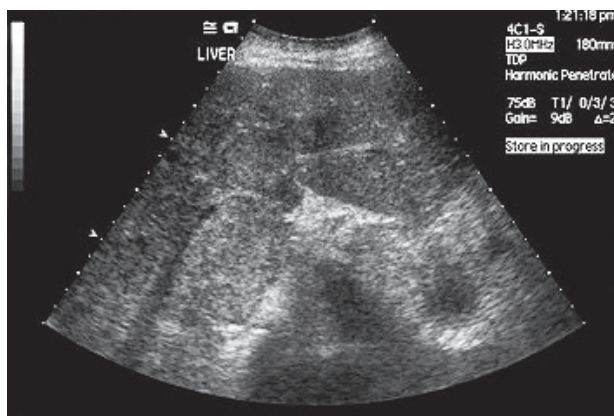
Liver ultrasound scan demonstrated multiple liver metastatic lesions.
